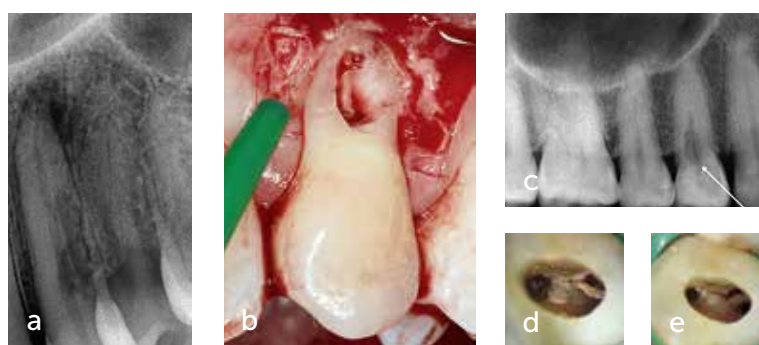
(a) Radiograph of an external root resorption on tooth 23. (b) Intraoperative view of the external root resorption on tooth 23. (c) Radiograph of an internal resorption on tooth 14. (d) Intraoperative view of the pulp chamber before detersion. (e) View of the internal resorption after detersion of the pulp chamber.
